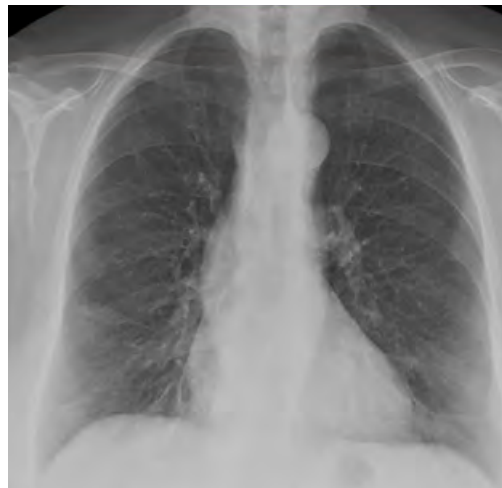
Above is a false-negative chest X-ray.
